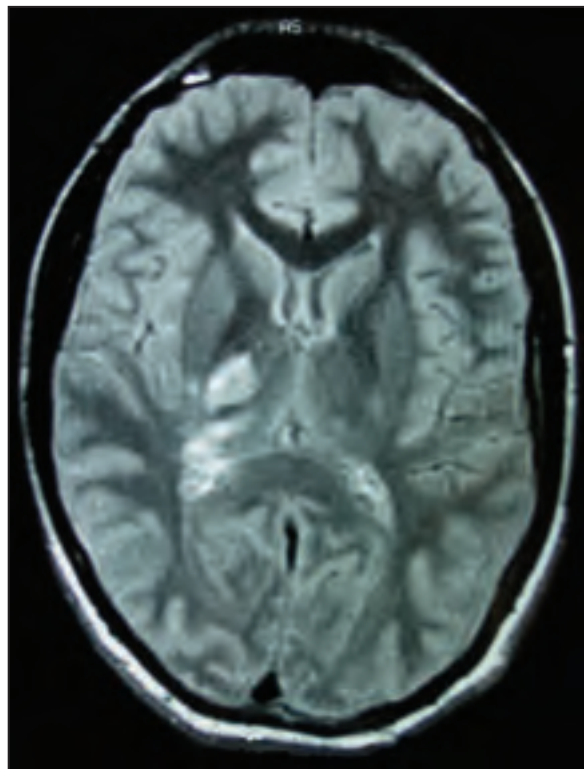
MRI scan: Acute ischaemic infarction in the territory of the right anterior cerebral artery (anterolateral choroidal arteries and striated thalamus) in sequence T2.
